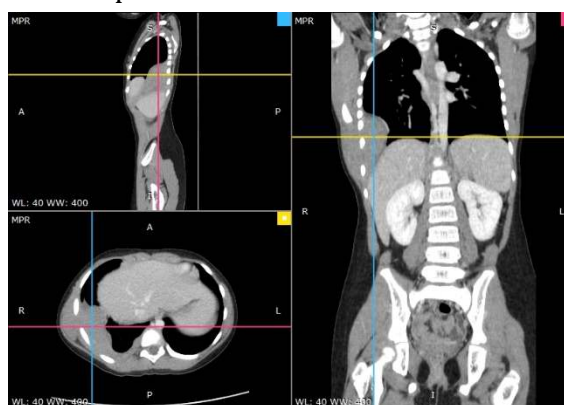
Image from initial CT scan showing
